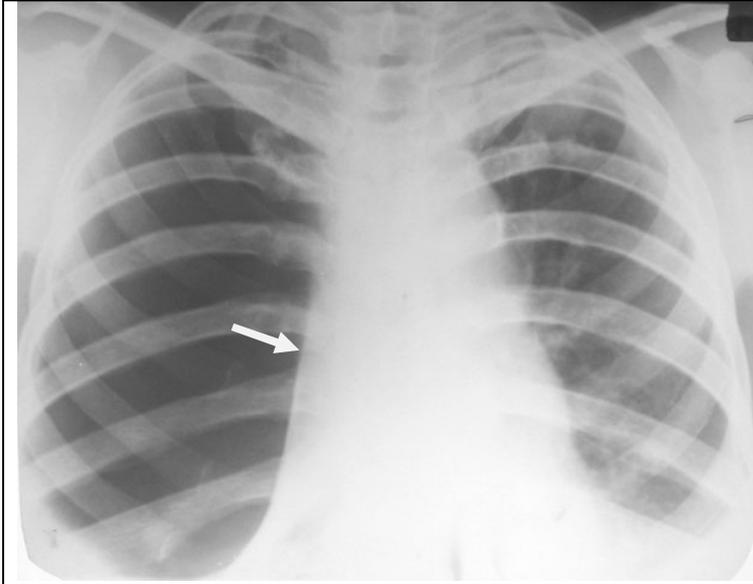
Anteroposterior radiograph shows asymmetrical hyperlucency in the right pulmonary field. Compression atelectasis of right lung (arrow). Pneumothorax.
